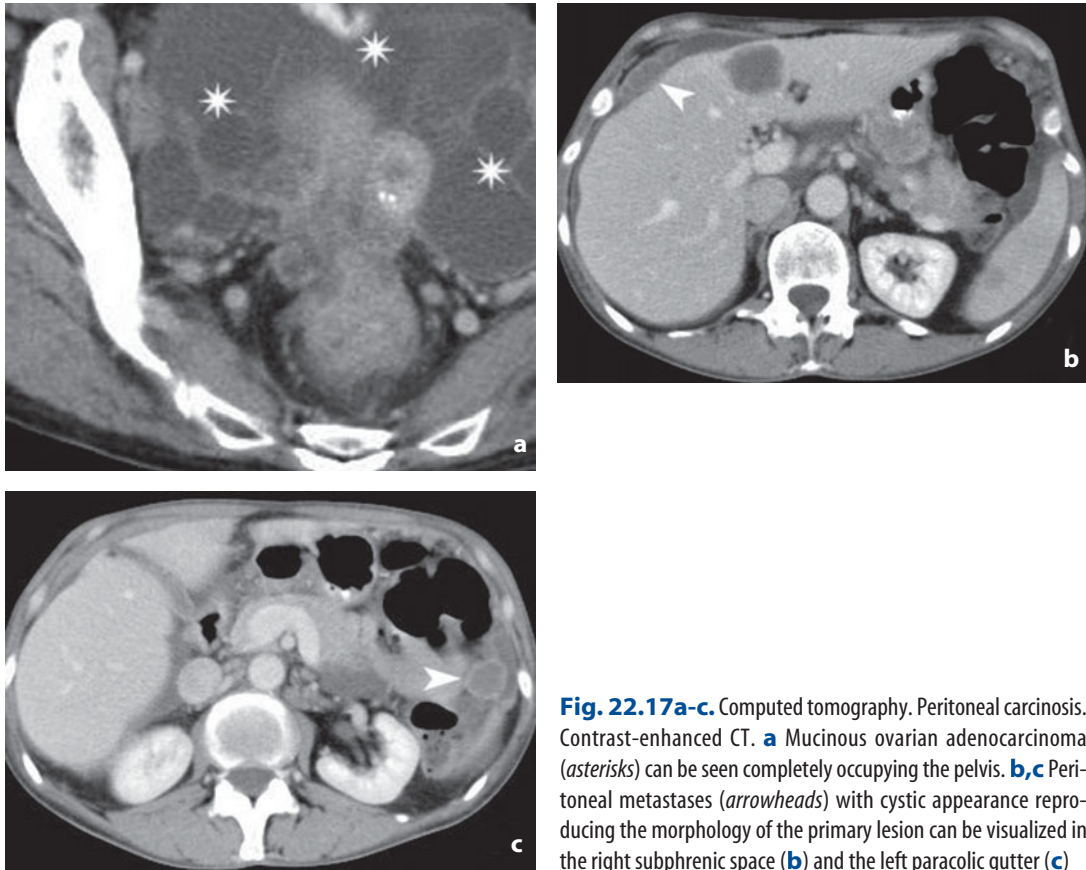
Computed tomography. Peritoneal carcinosis. Contrast-enhanced CT. a Mucinous ovarian adenocarcinoma (asterisks) can be seen completely occupying the pelvis. b,c Peritoneal metastases (arrowheads) with cystic appearance reproducing the morphology of the primary lesion can be visualized in the right subphrenic space (b) and the left paracolic gutter (c)
